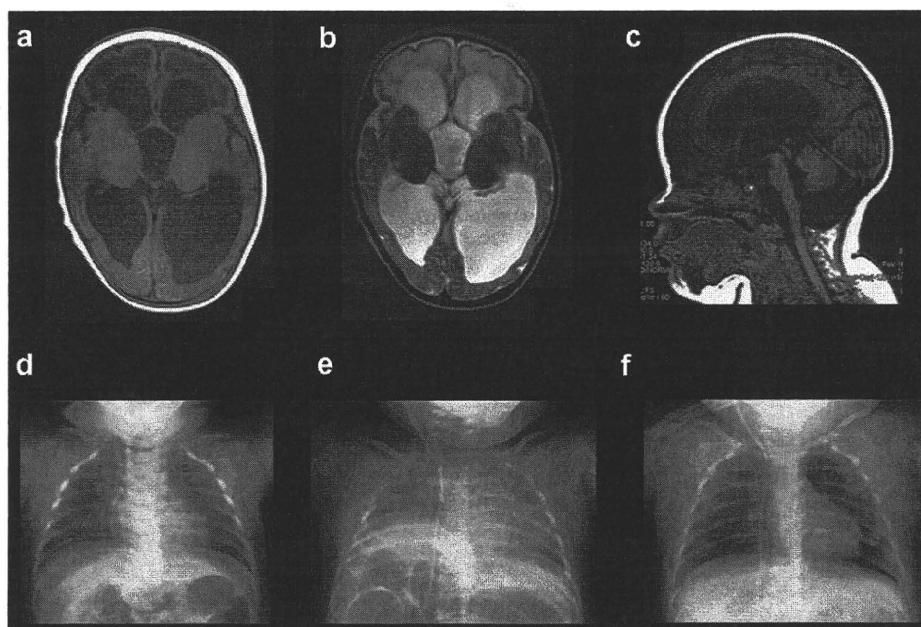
Brain MRI obtained at 2 months and chest radiographs. (a) Axial T1-weighted image shows marked dilatation of all ventricles indicating communicating hydrocephalus. (b) T2-weighted image shows hyperintensity of the bilateral frontal periventricular white matter. (c) Sagittal T1-weighted image shows mild hypoplasia of pons and cerebellum. (d) Chest radiograph reveals no abnormality at 3 months. (e) Chest radiograph at 8 months shows the right diaphragm elevation suggesting unilateral phrenic nerve palsy. (f) Intubation and mechanical ventilation effectively inflated the patient's lungs.
